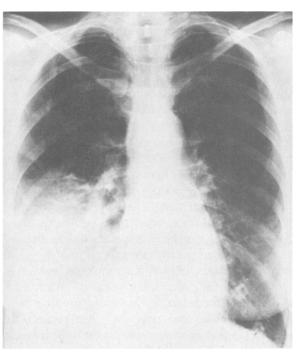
Posteroanterior roentgenogram of the chest showing consolidating right lower lobe infiltrate.
